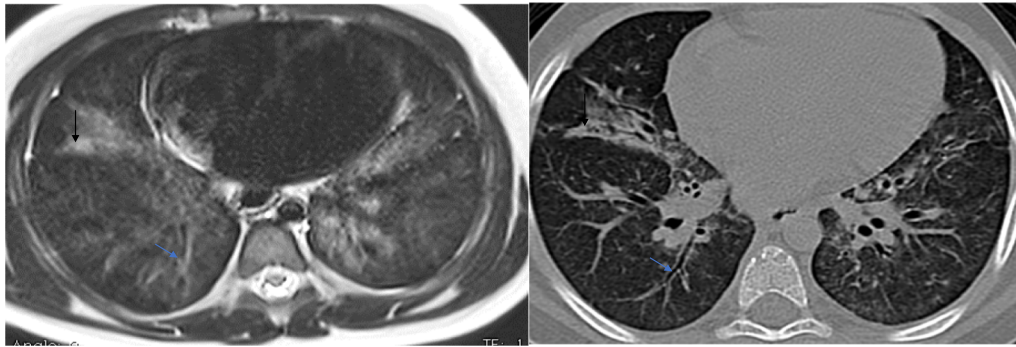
Male child with history of chronic aspiration due to esophageal dysmotility, T2 HASTE, and comparable HRCT cut; both show the score 1 bronchiectasis and bronchial wall thickening, score 2 bronchial generation (blue arrows), mucoimpaction (black arrows), ground-glass densities and centrilobular nodules, more delineated in HRCT (arrowhead). CT score 14, MRI score 10
